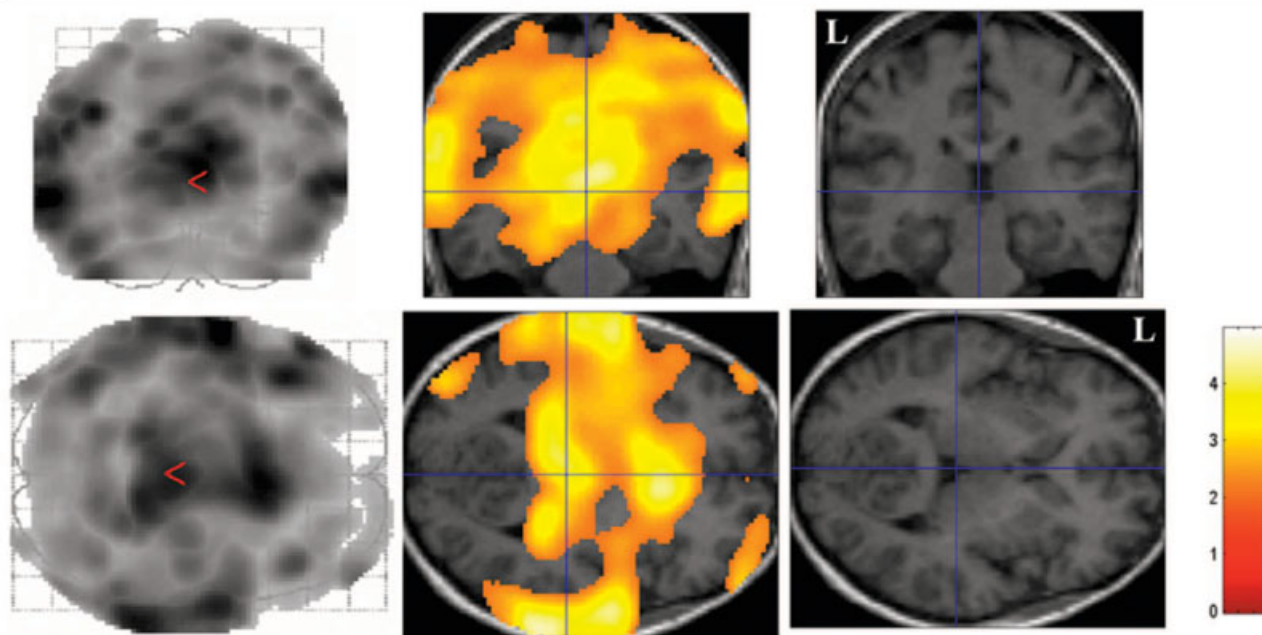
Brain areas with a significant decrease of $[^{123}\text{I}]5\text{-I-A-85380}$ distribution volume (V) in Parkinson's disease patients detected with a two-sample t test in Statistical Parametric Mapping version '02. Areas with a significant decrease are displayed in the glass brain (left) and on transverse and coronal slices through thalamus of a magnetic resonance (MR) image of a control subject (middle). Corresponding MR images without superimposition are shown on the right. Highlighted areas showed p less than 0.05 false-discovery rate, which was corrected for multiple comparisons. The area also showed cluster-level corrected p less than 0.001. Color bar shows T values with the maximum value of 4.96. Note that the glass brain view displays decreases in the entire brain superimposed to anteroposterior (top left) or top-bottom (bottom left) views, whereas the MR images with the superimposition display decreases on single slices.
